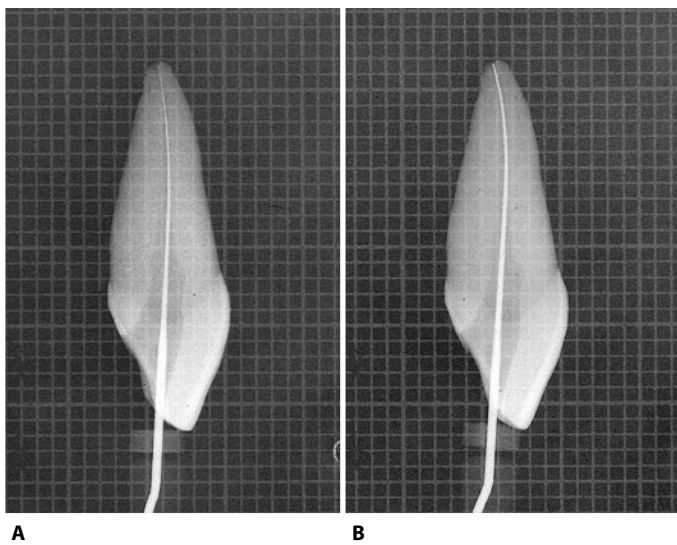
Radiographs to check the working length of the files. A. The first instrument at the radiographic terminus of the canal, to determine the working length. B. The last instrument at the radiographic terminus, to ascertain whether the working length is still correct (23 mm).
